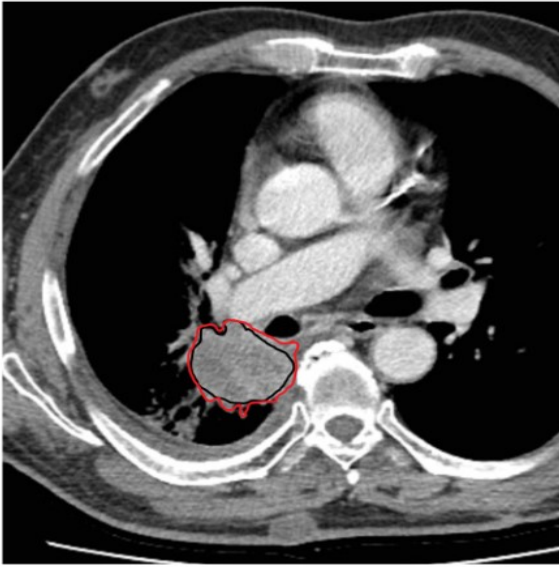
Manual segmentation of lung cancer on a CT image. Black and red ROIs differ due to inter-reader variability.²⁰
